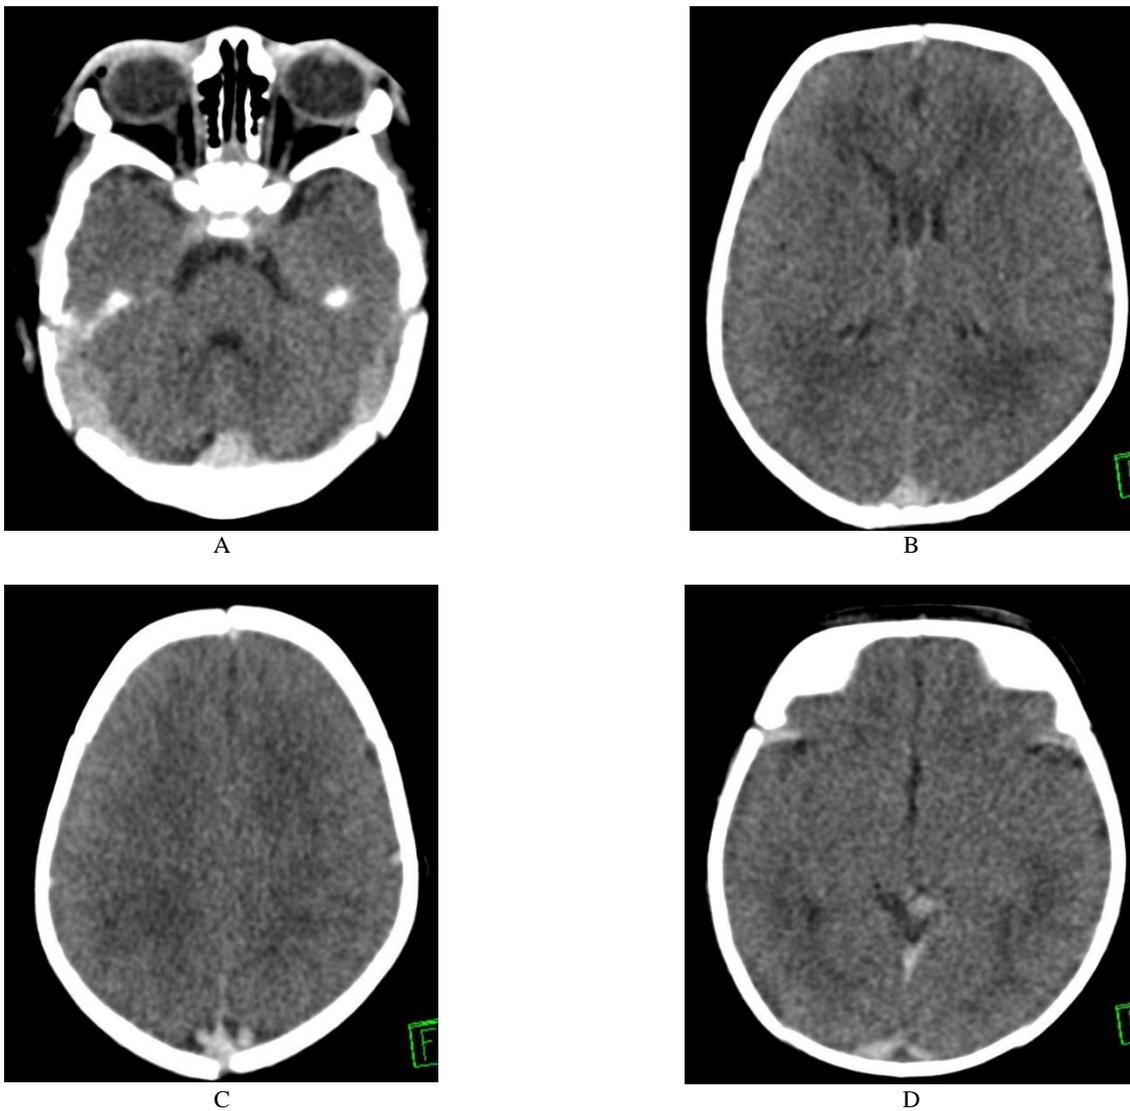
Non-contrasted CT brain scans showed dilated straight sinus, bilateral transverse sinus (A and D), and superior sagittal sinus (B and C) with hyperdensity within, suggestive of thrombosis.
